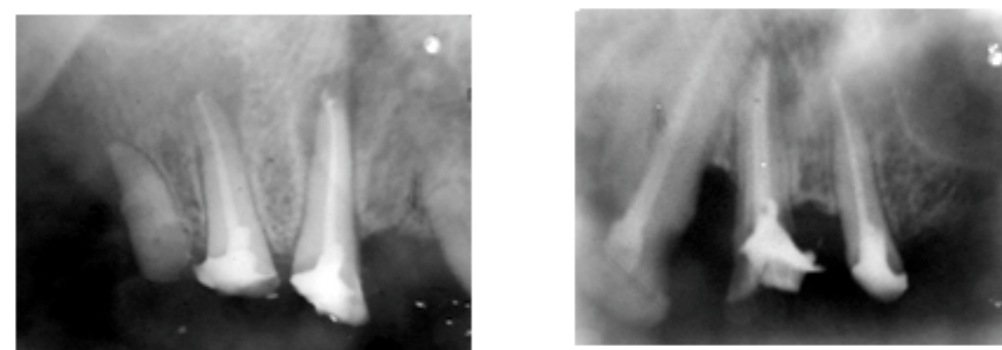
Radiograph of broken down teeth
